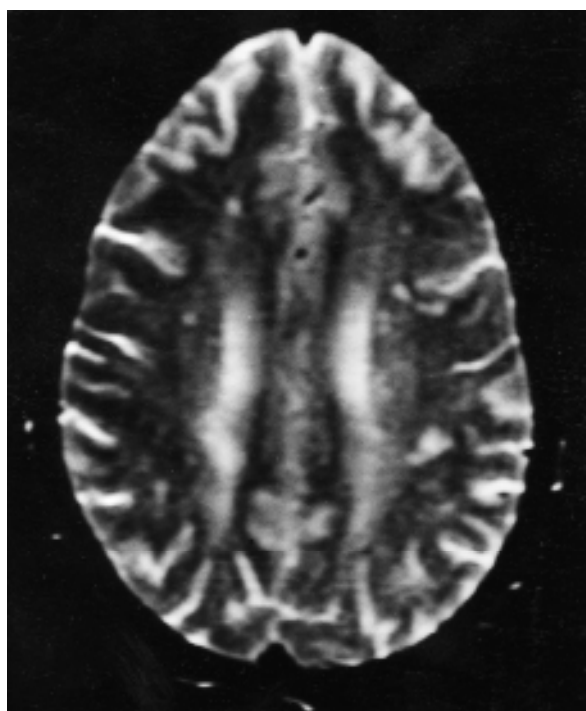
Cerebral MRI of a young Fabry patient showing multiple subcortical small vessel infarcts.
